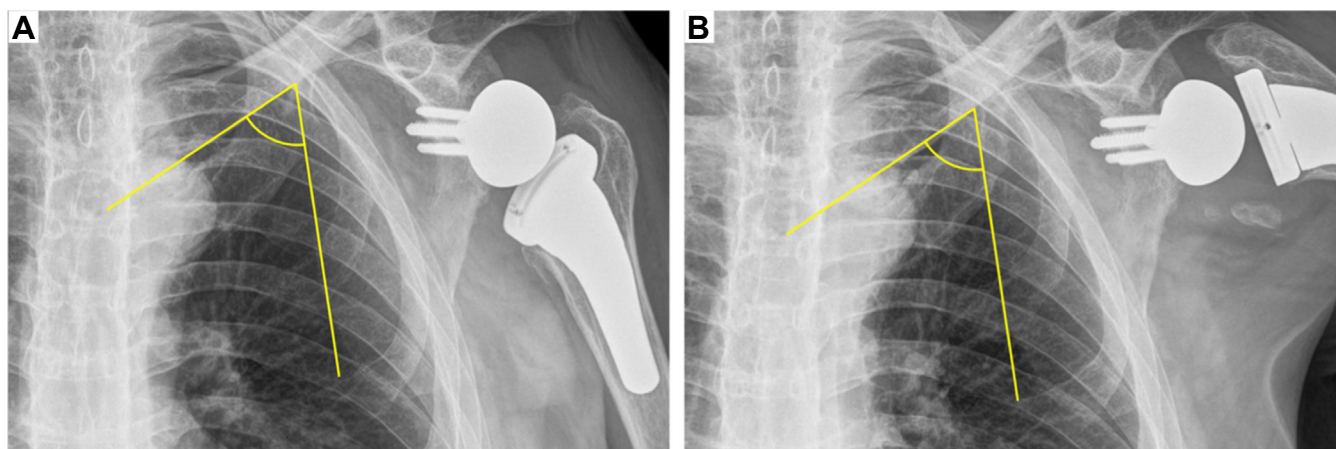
Anteroposterior resting (A) and dynamic (B) abduction radiographs of the Left shoulder joint following the first arthroplasty, highlighting the lack of scapular motion.
